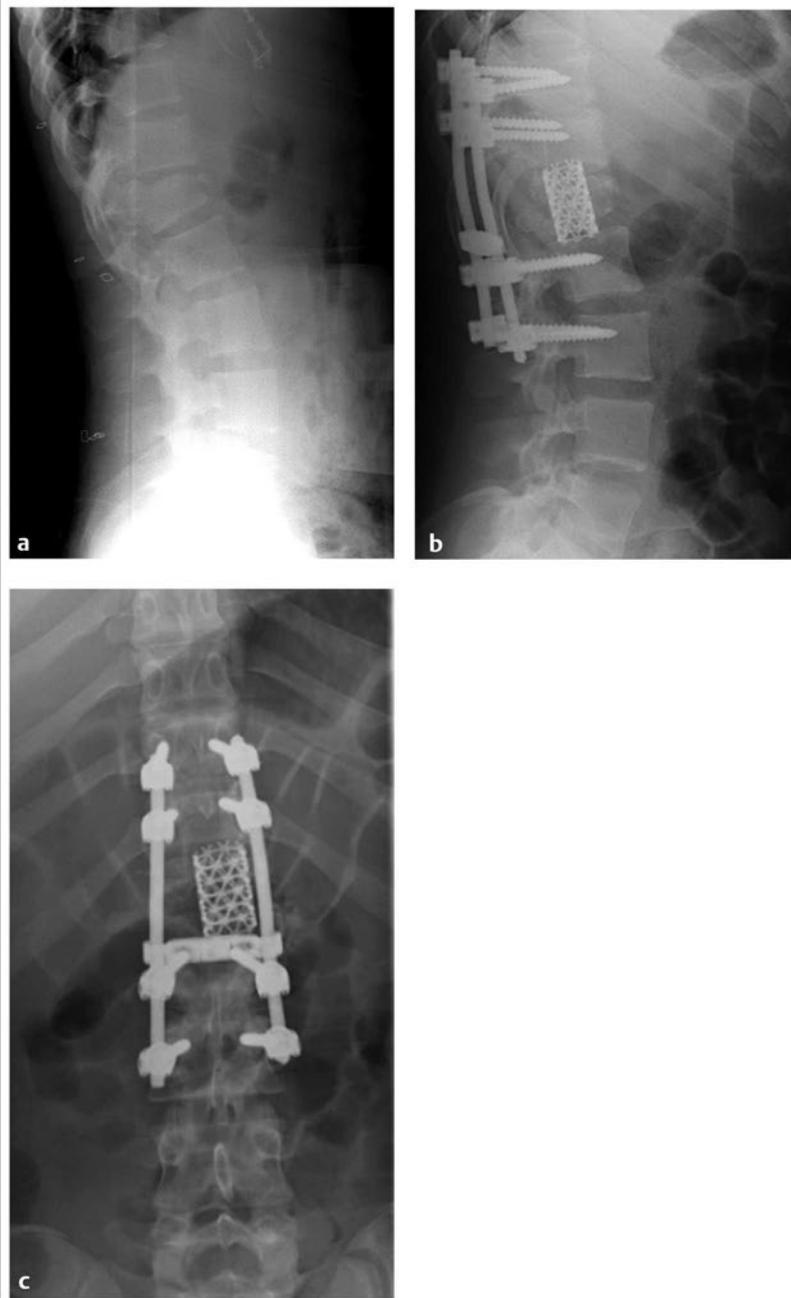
L1 burst fracture. (a) Lateral radiograph demonstrating an unstable burst fracture of L1 in a 16-year-old girl who presented with an incomplete spinal cord injury following an all-terrain vehicle accident. The patient underwent decompression and stabilization through a posterior approach. Postoperative (b) lateral and (c) anteroposterior radiographs demonstrate an L1 corpectomy, placement of a metallic interbody cage, and placement of posterior segmental instrumentation and fusion from T11 to L3.
